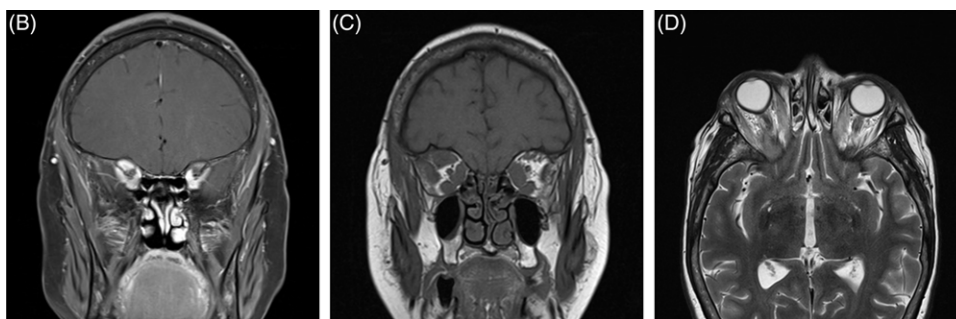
T1-weighted post-contrast coronal image demonstrating very severe crowding in the orbital apex, greater on the right; Figure 1C: T1-weighted coronal image through posterior orbits showing severely enlarged all extraocular muscles; Figure 1D: T2-weighted axial image demonstrating enlargement of predominantly posterior portion of all extraocular muscles.
